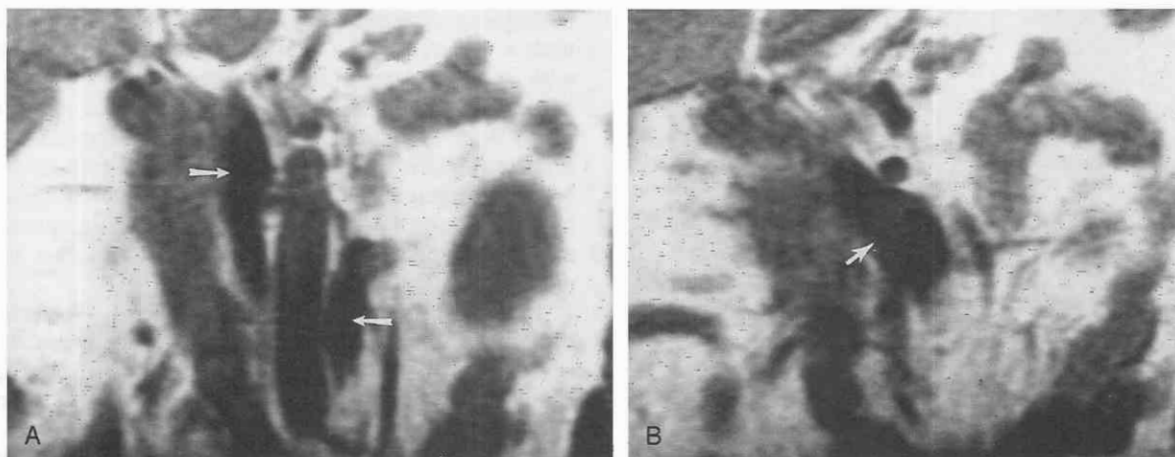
Duplicated inferior vena cava. *A*, Coronal T1-weighted, spin-echo MR image shows portions of both the right and left inferior venae cavae (arrows). The left inferior vena cava is located entirely caudad relative to the level of the left renal vein. *B*, MR image in a more anterior location demonstrates the enlarged left renal vein (into which the left inferior vena cava has emptied) (arrow) crossing the midline to drain into the right inferior vena cava.
